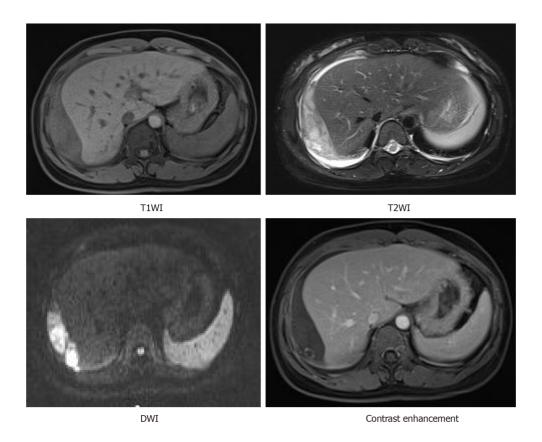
Magnetic resonance imaging scan showed a curved mixed signal beneath the subhepatic space, mostly low in T1-weighted imaging and high in T2-weighted imaging. Diffusion-weighted imaging showed restricted diffusion. A peripheral enhanced nodule was observed within the mixed curved signal after administration of gadolinium. T1WI: T1-weighted imaging; T2WI: T2-weighted imaging; DWI: Diffusion-weighted imaging.
